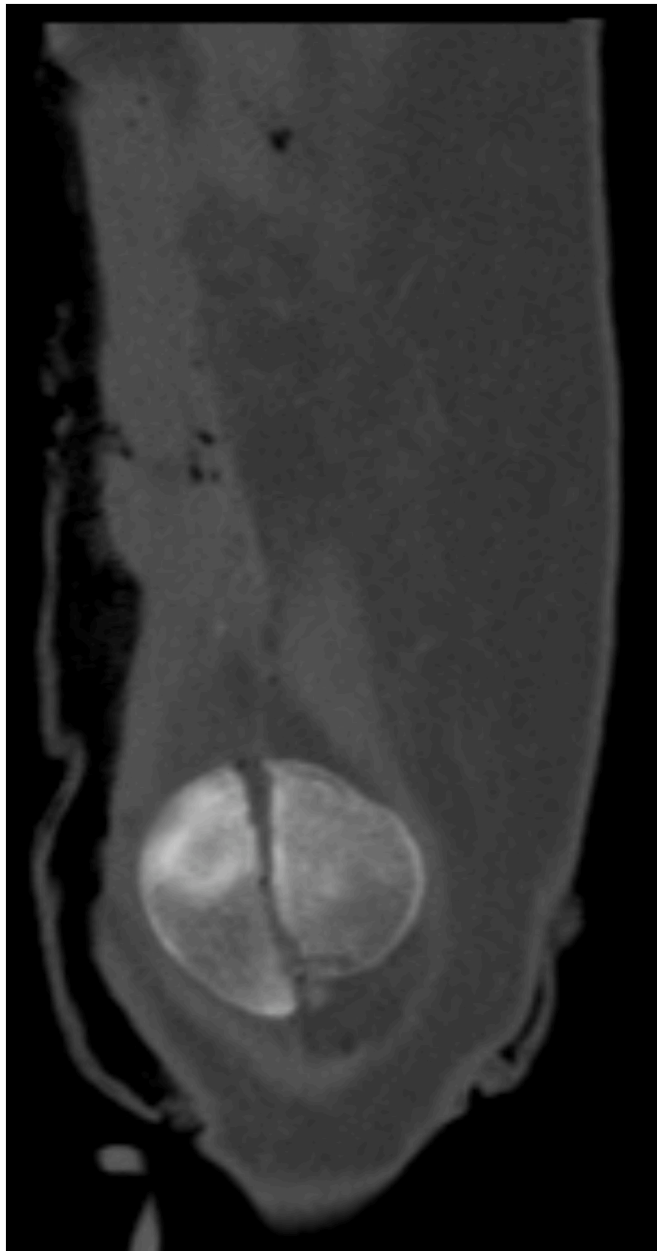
CT-scan of the patella: Coronal image of the longitudinal fracture of the right patella.
